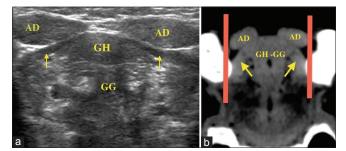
(a) Coronal section in submental location using linear transducer, demonstrating sonoanatomy of step 2a structures (anterior floor of mouth). (b) Corresponding computed tomographic section (red lines – representing limit of ultrasound scan extent) AD: Anterior digastric muscle; GH: Geniohyoid muscle; GG: Genioglossus muscle; Yellow arrows, Mylohyoid Muscle
